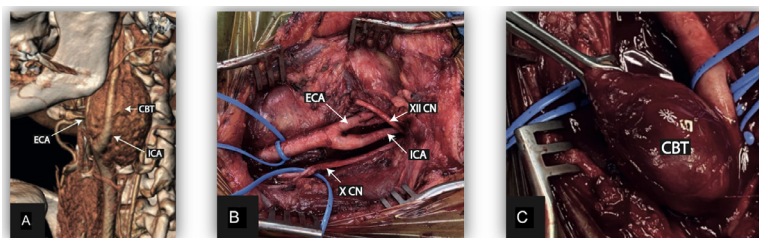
A) 3D computed tomography reconstruction of the carotid body tumor, B) relations to the neighboring tissues (tumor excised), and C) mobilization of the carotid body tumor before the final resection.
